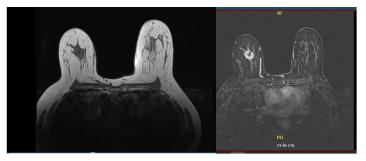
Breast MRI post AC - T2 and FLAIR.
